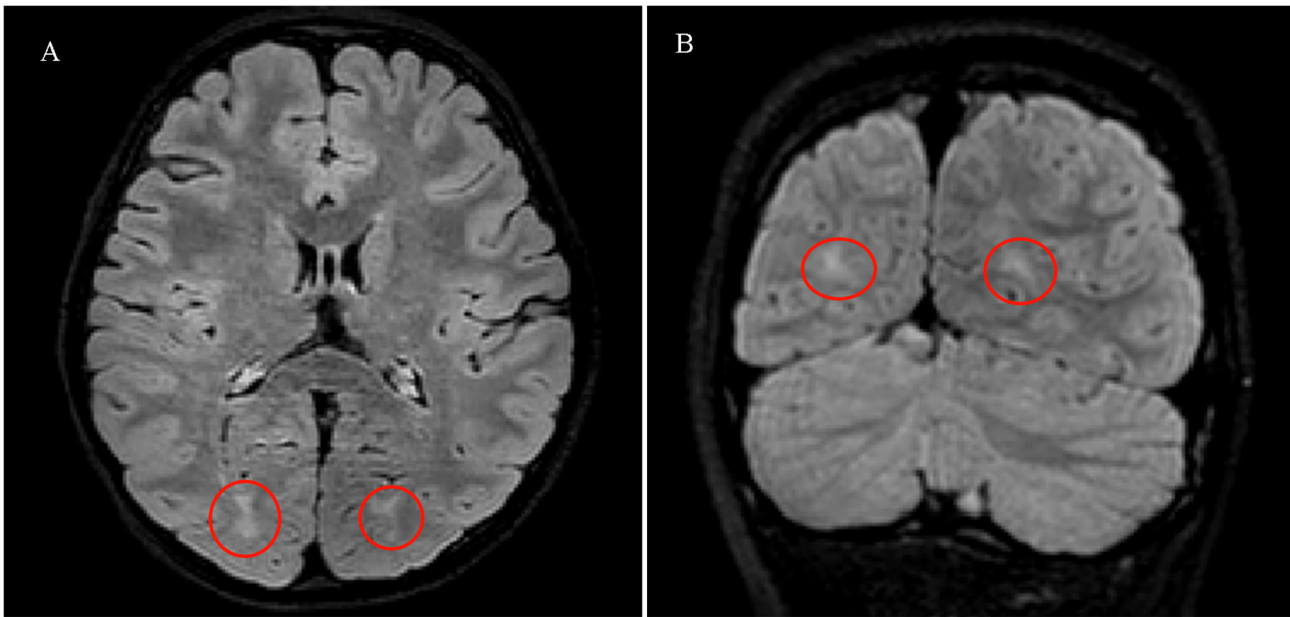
Cranial MRI of the patient. (A) axial view and (B) coronal view. The bilateral cerebral hemispheric structure was symmetrical and the brain white matter contrast was normal. However, patchy foci of slightly high T2-fluid-attenuated inversion recovery abnormal signals were observed in the bilateral occipital lobes (as indicated by the red circles).
